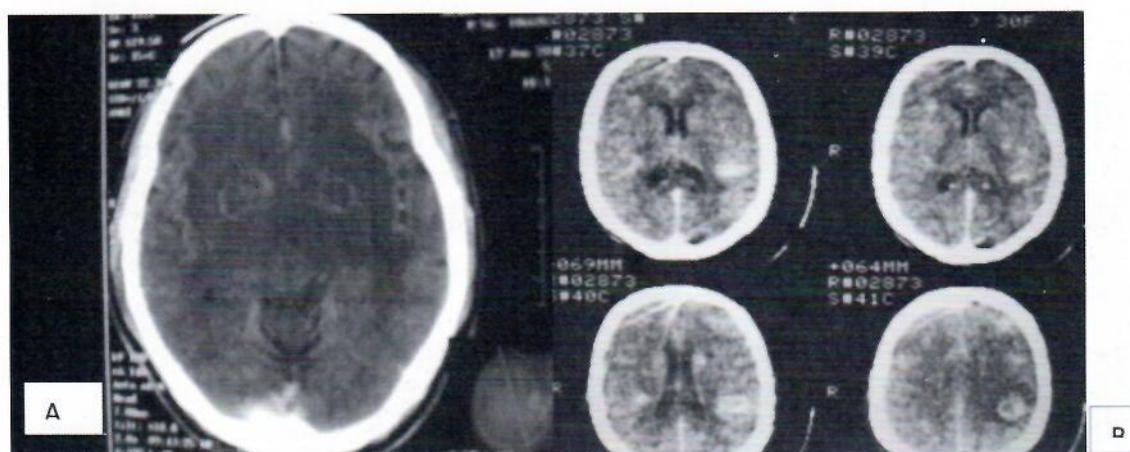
(A) An axial contrast enhanced CT scan showing multiple ring enhancing lesions in the basal ganglia region bilaterally in keeping with intracranial toxoplasmosis. (B) Another contrast enhanced CT scan of a patient with left parietal tuberculoma.
